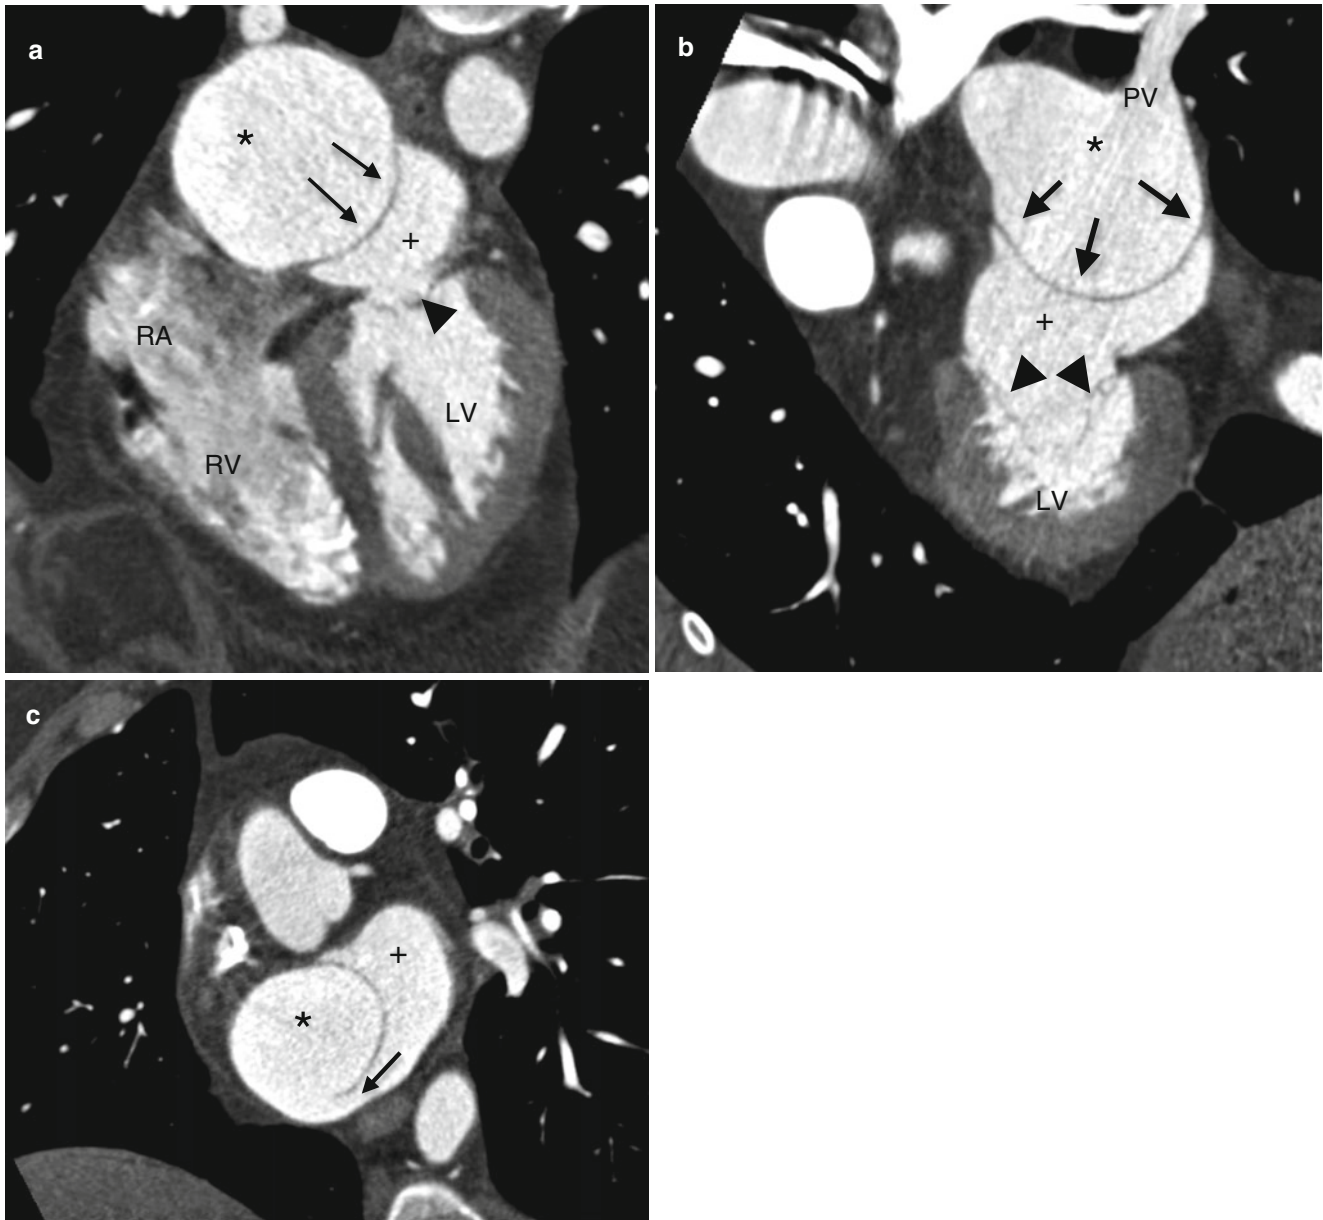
Cor triatriatum in a patient with shortness of breath treated for suspected exertional asthma. Panel (a) is a four-chamber computed tomographic (CT) view demonstrating the membrane separating the upper left atrial section (*asterisk*) which is dilated from the lower section (*plus sign*). The *black arrowhead* points to the mitral valve. Panel (b) is a two-chamber CT again showing the membrane (*black arrows*)
